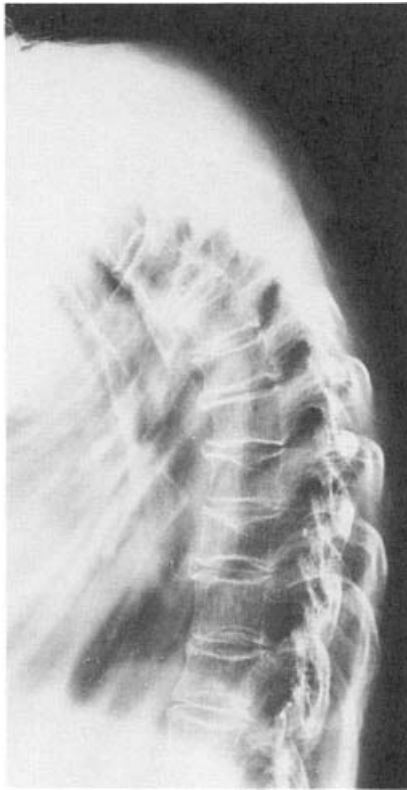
Vertebral body deformity (“cod-fish” vertebrae) in a 48-year-old woman with OI type I. The lateral spine X-ray demonstrates marked osteopenia, kyphosis, and deformation of the vertebral bodies by the intervertebral discs. The radiograph is courtesy of Drs. David Rowe and Jay R. Shapiro.
